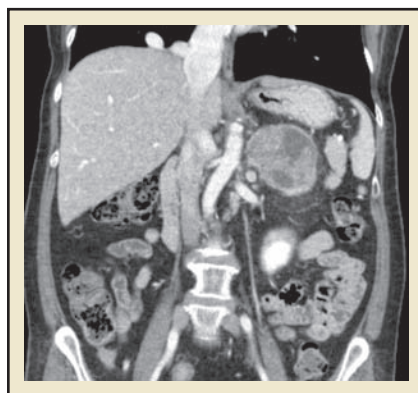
Computed tomography scan with contrast showing a 6.3-cm heterogeneous left adrenal lesion.
